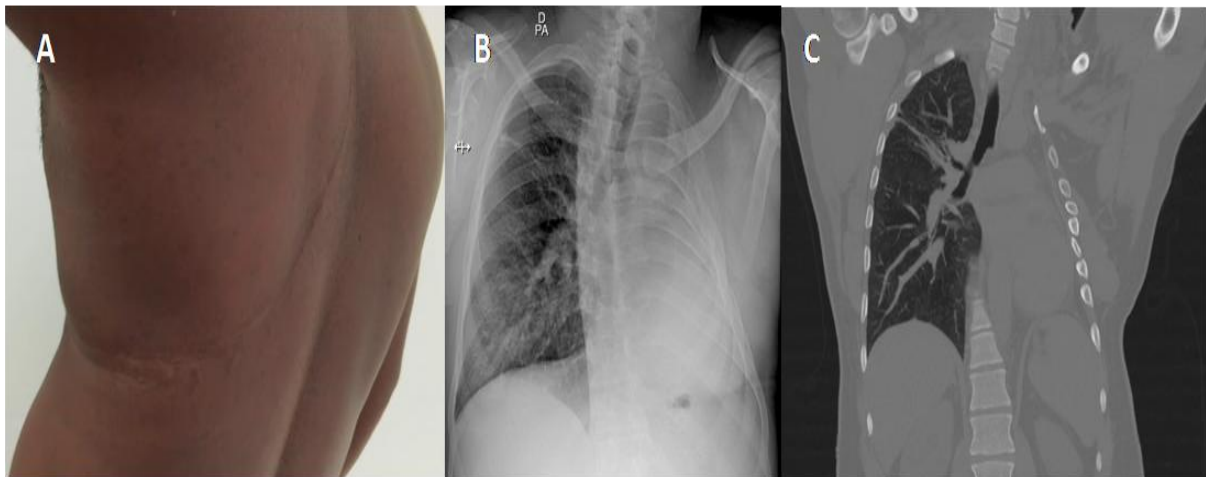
(A) Extensive left posterior thoracotomy scar. (B) Chest radiography showed homogeneous opacification of the left hemithorax with a marked ipsilateral shift of the mediastinum and trachea. Computed tomography. (C) Computed tomography confirmed the complete absence of the left lung, severe volume loss, and a marked ipsilateral shift of mediastinal structures.
